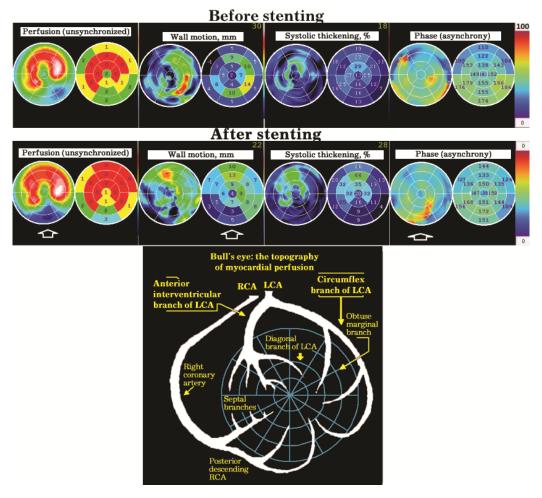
Perfusion single photon emission computed tomogram of the left ventricle myocardium in patient Sh.P.I.
